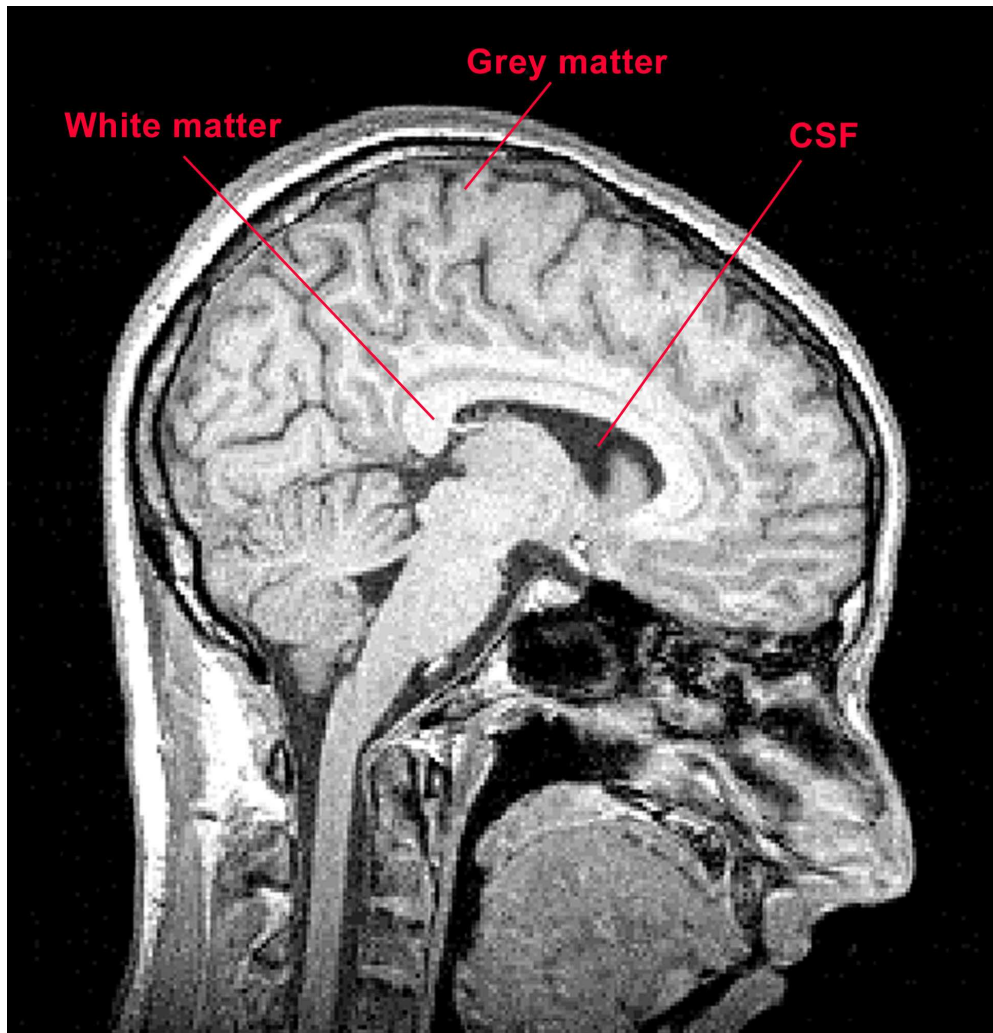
A T1-weighted MR image of the living human brain (the brain of the author, in fact!). MRI allows for a clear delineation between the three fundamental tissue types of the brain: the grey matter (e.g. in the parietal cortex), white matter (e.g. in the corpus callosum), and cerebrospinal fluid (e.g. in the lateral ventricles)
